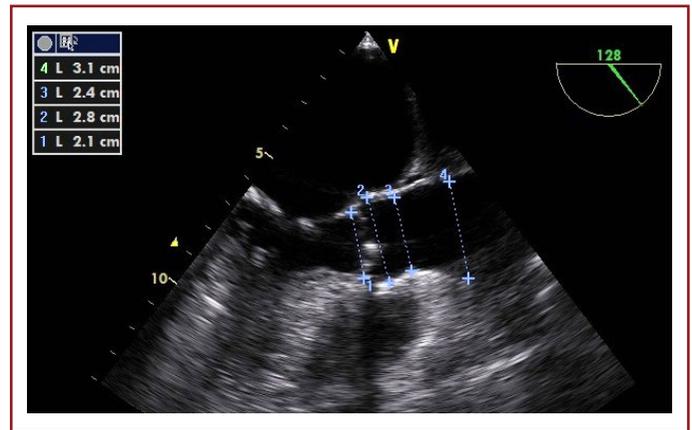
Measurements of the aortic annulus, sinus of Valsalva, sinotubular product, and resultant aortic diameters at the mid-systole using transesophageal echocardiography from a longitudinal axis section.
